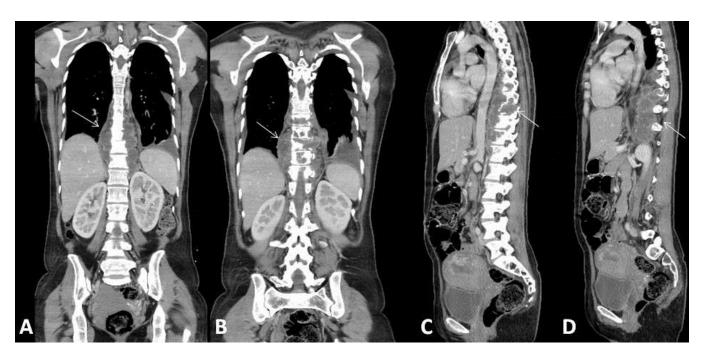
A 30 year old female with atypical spinal tuberculosis. Contrast enhanced CT of the chest and abdomen. A, B-Reconstructed coronal images. C, D- Reconstructed sagittal images showing contiguous multi-level vertebral involvement in the lower thoracic levels with destruction and associated large paravertebral lobulated abscess (arrows). Technique: Multi detector CT scanner (64 slice), mAs 91.7, kV 120, 3mm slice thickness. Porto-venous phase of contrast study using 100 ml Omnipaque (300mg I/ ml).
